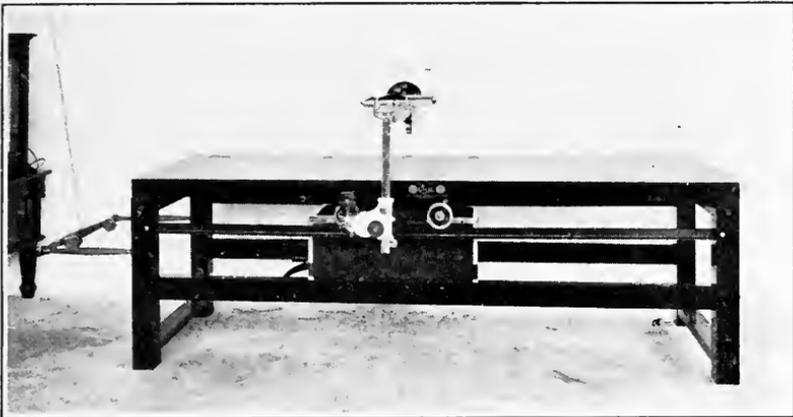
TYPE OF ROENTGENOSCOPIC TABLE SUPPLIED THE U. S. GOVERNMENT, SO CONSTRUCTED THAT INJURED SOLDIER MAY BE EXAMINED FROM HEAD TO FEET WITHOUT BEING MOVED. (Courtesy of Campbell Electric Company, Lynn, Mass.)
